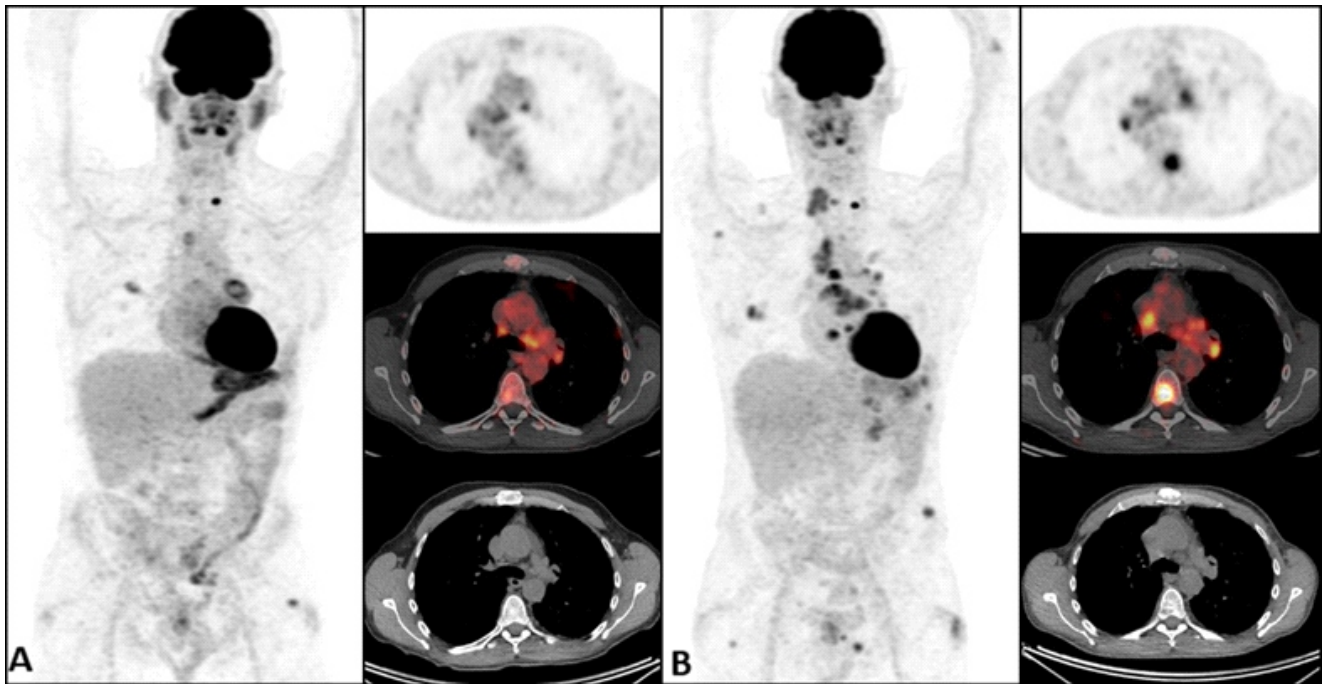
Maximum intensity projection and axial PET, fused PET/CT and CT images showing A: Early response to treatment, and B: Progression of bone and lymph node metastases due to 2-months long therapeutic break in a patient with renal cell cancer.
